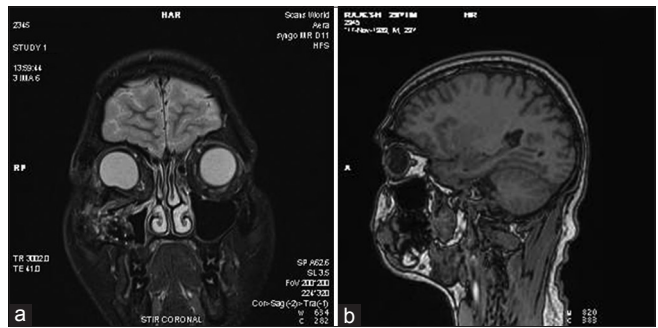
(a and b) MRI scan image showing warping of the graft and subsequent compression of orbital contents
